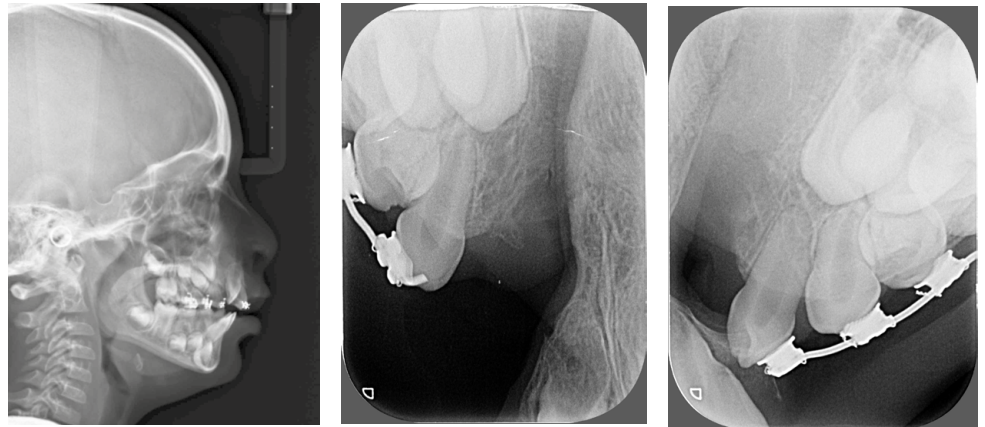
(a, b and c), Periapical radiographs revealing an extensive bilateral bone defect, while lateral cephalometric radiograph certified significant premaxillary protrusion and downward displacement.
